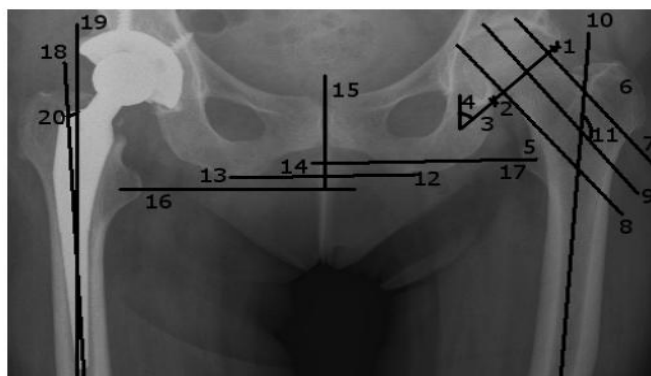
Parameters important in Hip Replacement, extracted from an anterior-posterior radiography
